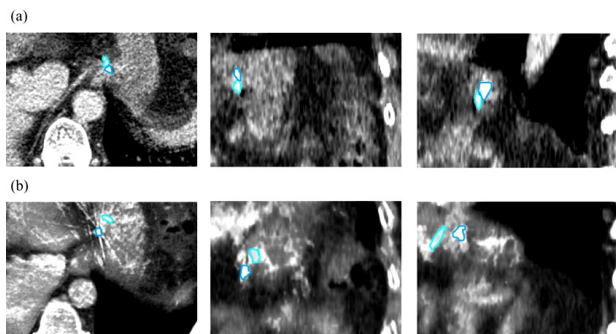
(a) Clips on a fused 4DCT image; (b) Clips on a fused CBCT image.
